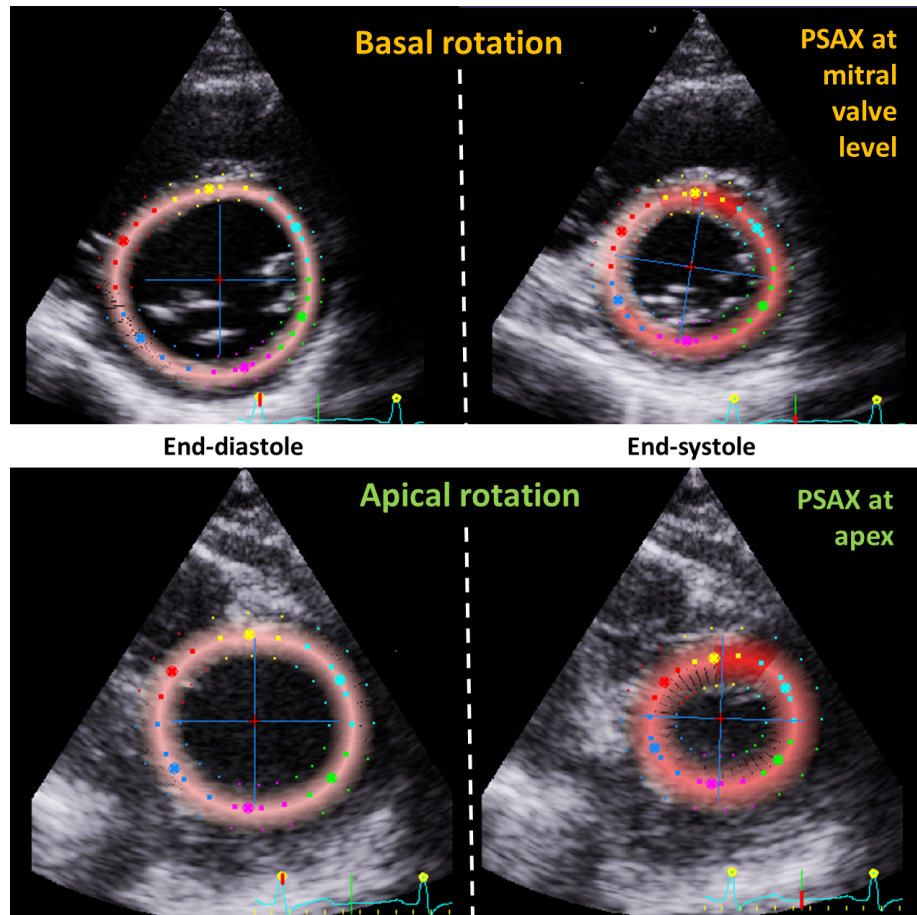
Apical and basal rotation at end-diastole and end-systole measured from a parasternal short axis (PSAX) images at the mitral valve level and apex. The net basal and apical rotation is termed twist.
